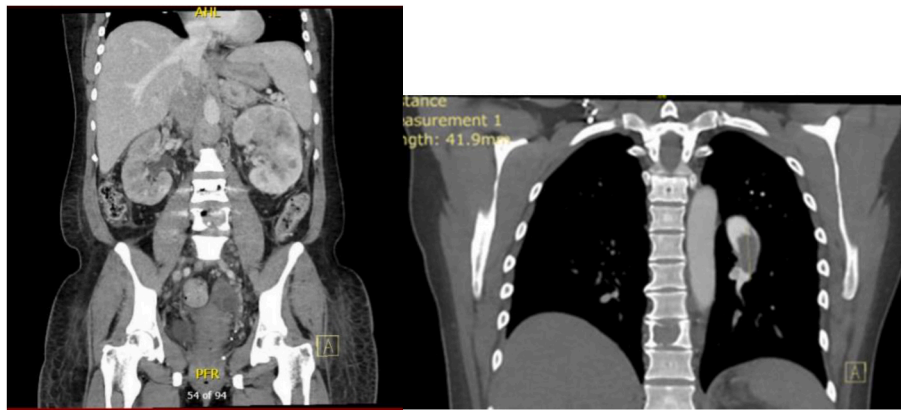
Coronal CT Chest/abdomen/pelvis demonstrating RCC with extension of IVC thrombus above renal vein but below hepatic vein (Level II).
